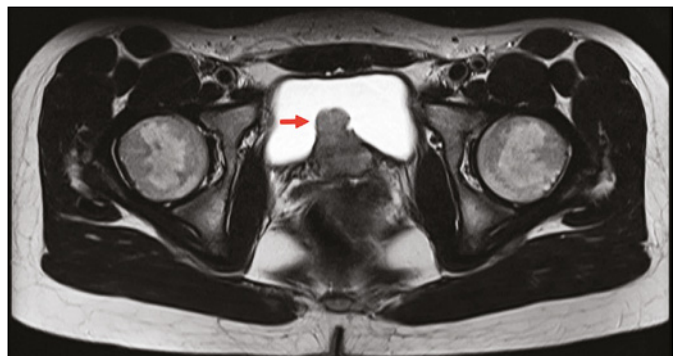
Contrast enhanced magnetic resonance imaging showing paraganglioma on the posterior bladder wall (arrow).
